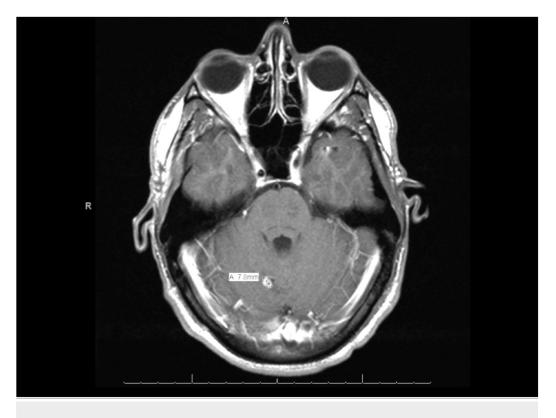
MRI One Month Post-Resection
